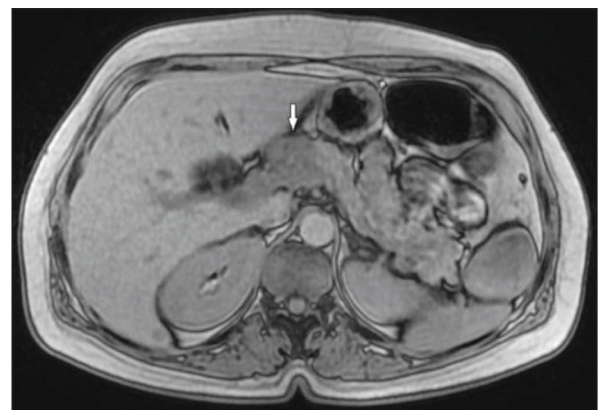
Abdominal magnetic resonance image of a mass in the head of the pancreas; axial section.
